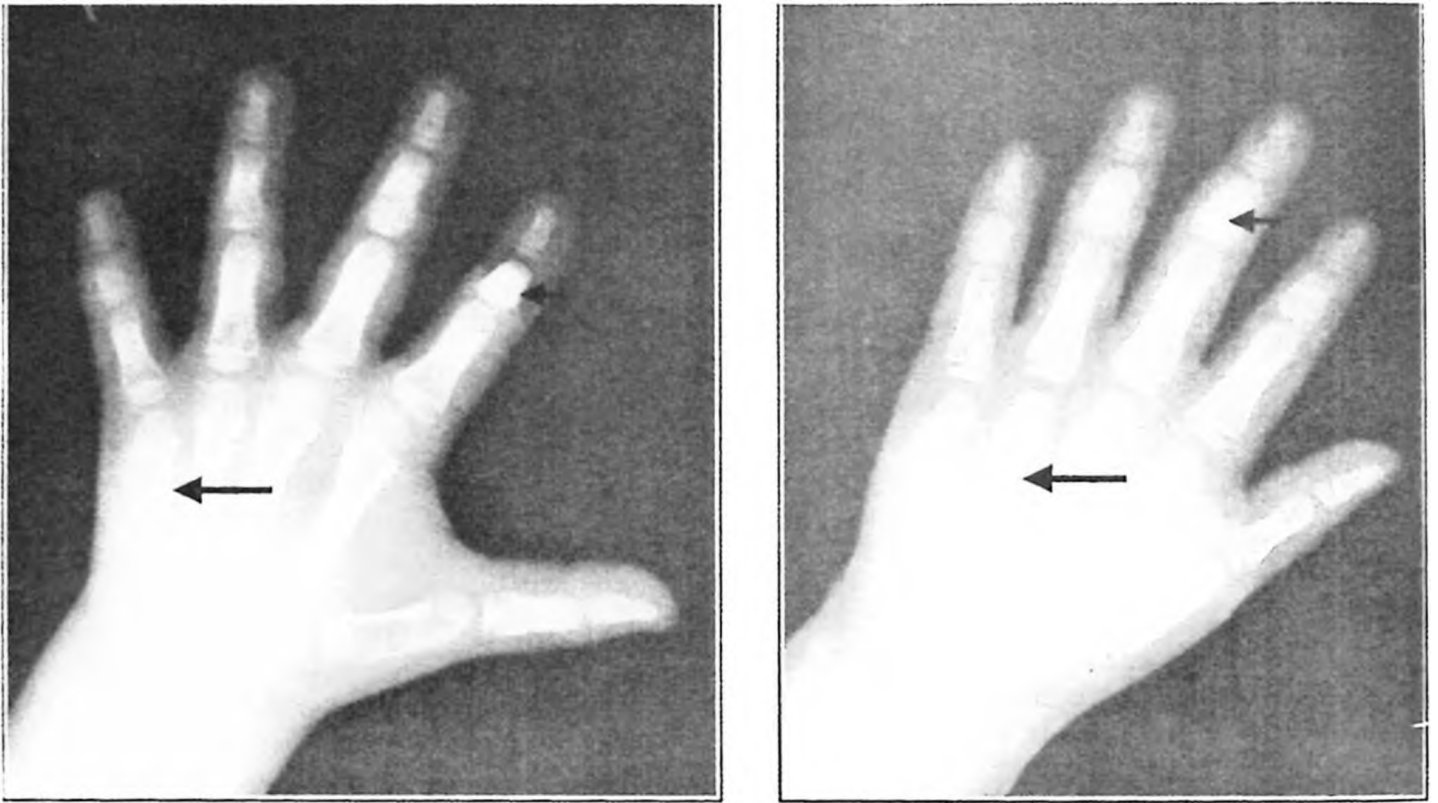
Hand X-rays of a six-year-old Turkish boy and a 5 1/2-year-old Japanese boy with brachydactyly type E. The large arrows indicate the shortened metacarpal bones, which define this form of brachydactyly. The phalanges are also shortened. Additionally, cone-shaped epiphyses are present (small arrows).
